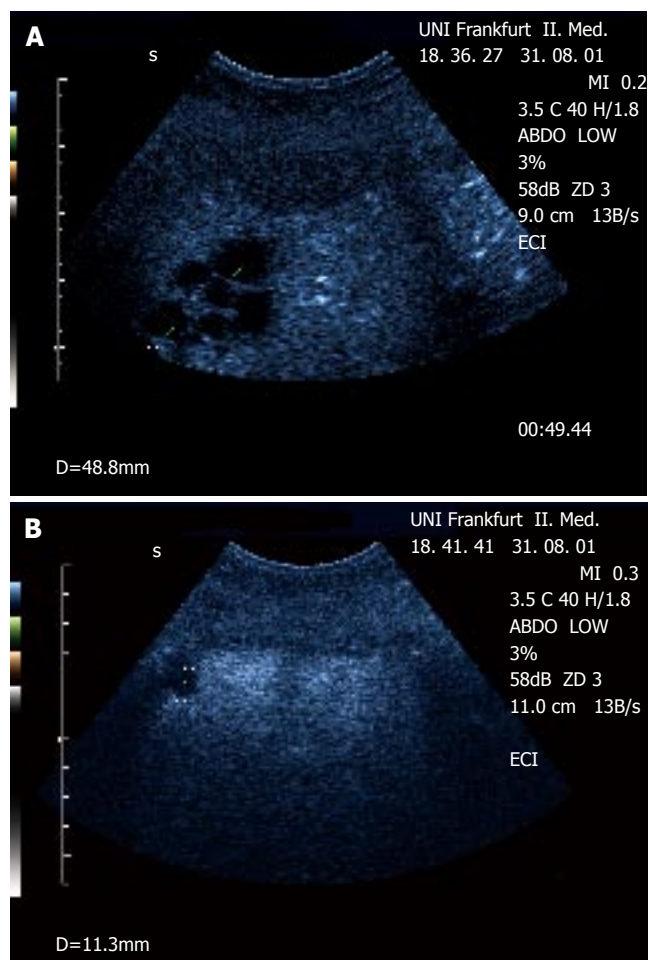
Demonstration of a focal (multicystic) lesion in a patient with cervix carcinoma using contrast-enhanced ultrasound (CEUS). A: The lesions can be delineated in the portal-venous phase as 'black spots' lacking portal-venous enhancement within normally enhanced liver tissue. B: An additional small lesion next to the diaphragm (not visible in native B-mode) was detected by CEUS but not with CT. Biopsy confirmed metastatic disease.
